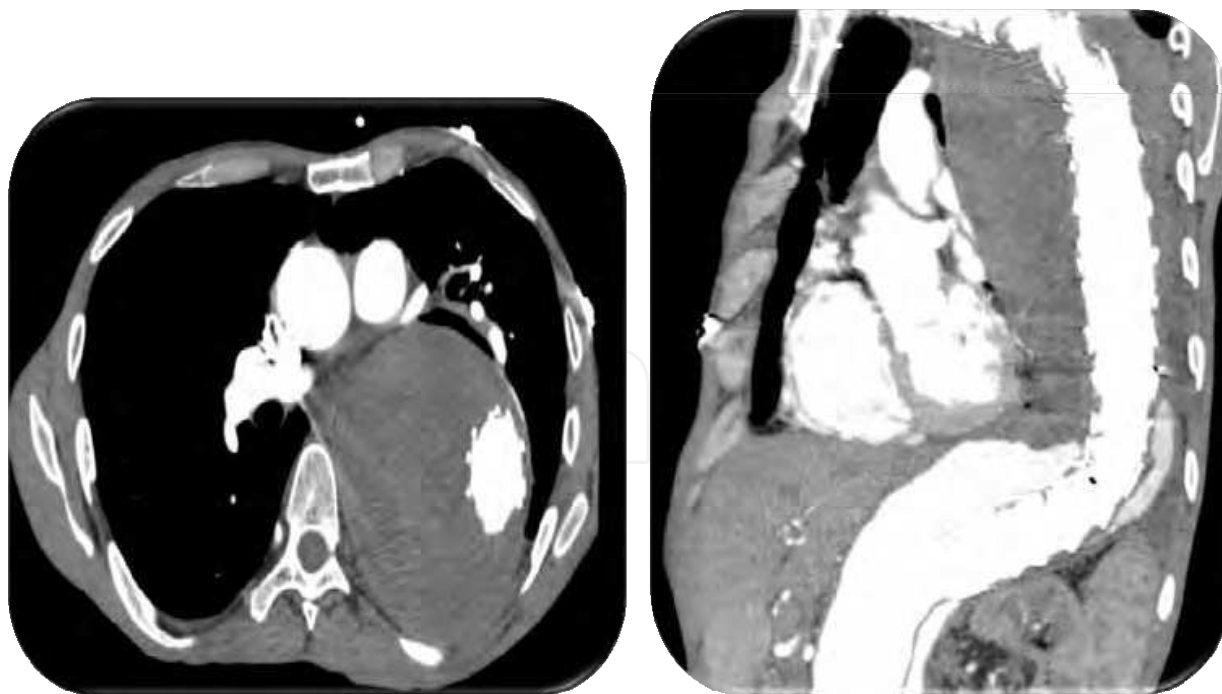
Case 5. Left: Chest computed tomography scan showing sac growth (11 cm in diameter) in the descending thoracic aorta. Right: Dissection of the distal thoracic aorta and visceral aorta, with a huge thoracic postdissection sac.
